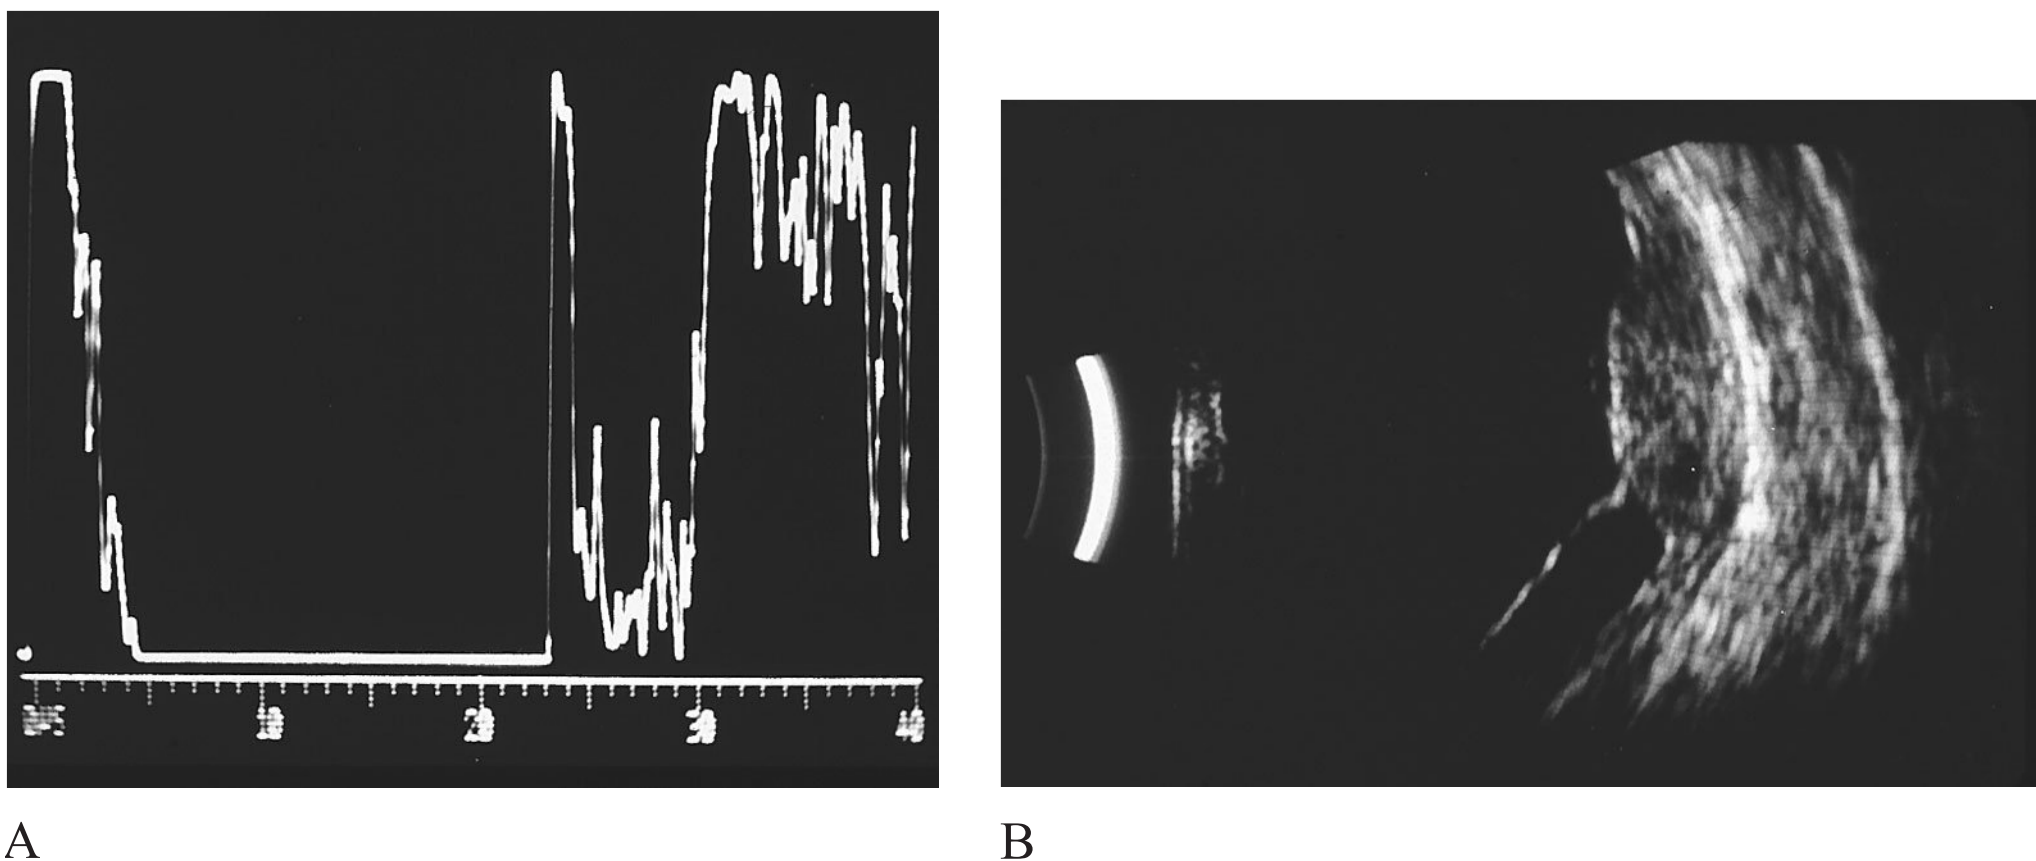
(A) An A-scan ultrasound of the mass in the right eye revealed low internal reflectivity. (B) A B-scan ultrasound of the mass in the right eye revealed a mass with overlying exudative retinal detachment without extrascleral extension.
